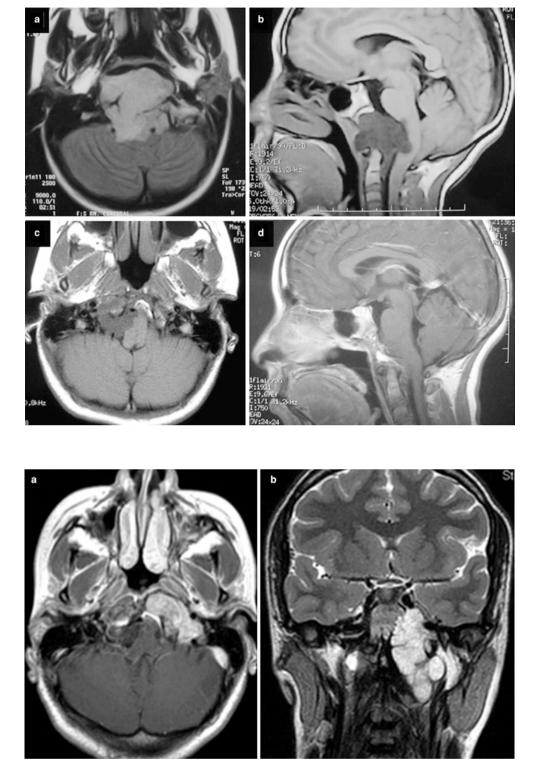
Axial (a) and coronal (b) magnetic resonance imaging demonstrate a recurrent chordoma of the left petrous bone, with infratemporal and parapharyngeal extension
